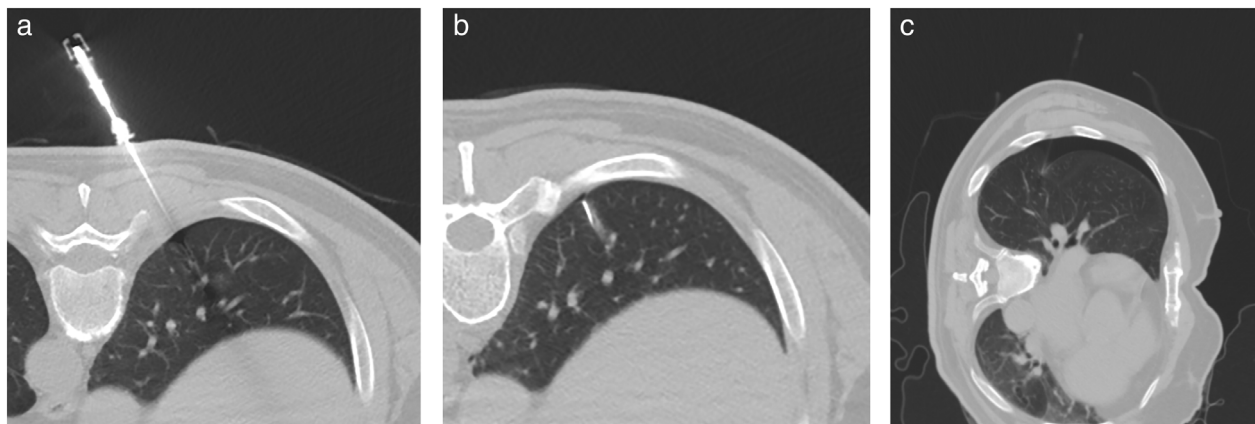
The dimpling of visceral pleura during preoperative CT-guided localization (POCTGL). (a) A hookwire with the sheath needle punctured through the pleura and pleura dimpling occurred. (b) The sheath needle was withdrawn, and the dimpled visceral pleura returned attached firmly with the parietal pleura without air in the pleural space. (c) A spinal needle was used to try to puncture through the visceral pleura in the case with iatrogenic pneumothorax. The visceral pleura lost its negative pressure, outward support, strength, and showed a deep dimple
